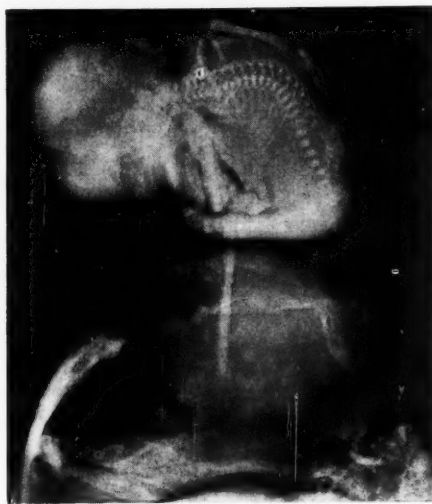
Case 5. Roentgenogram of fetus papyraceous after delivery. Ossification centers indicate a fetal age of 14 weeks.
